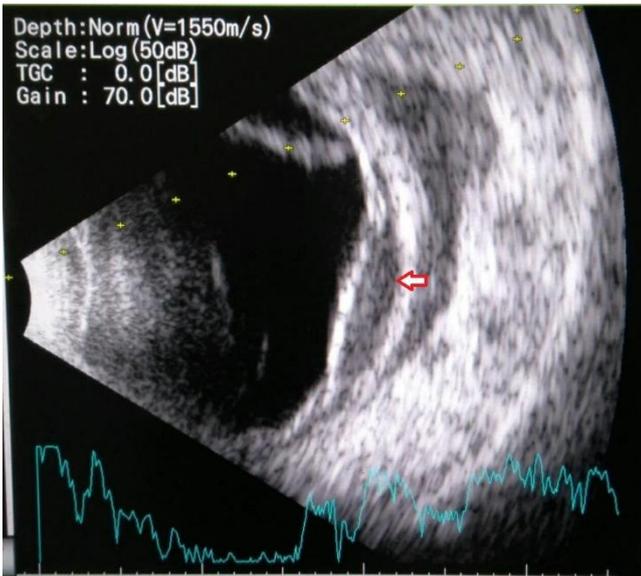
Orbita Ultrasonography (red arrow shows choroidal detachment)
